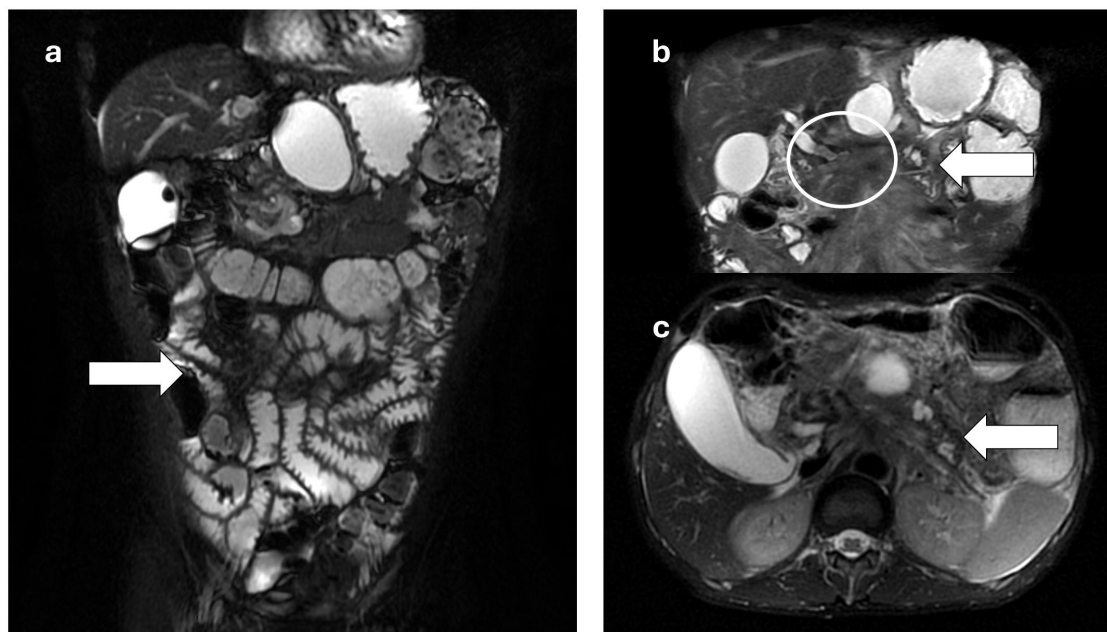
Magnetic resonance images showing signs of CD and concomitant pancreatic cancer. (a) Coronal T2 scans showing increased ileal folds (ileal “jejunalization”, arrow), as expected in CD. (b-c) Coronal and axial T2 scans showing pancreatic pathological tissue, pancreatic tail atrophy with pancreatic duct dilatation (arrow in both), stenosis of common bile duct (circle in both), portal thrombosis and cavernomatosis (circle in b).
